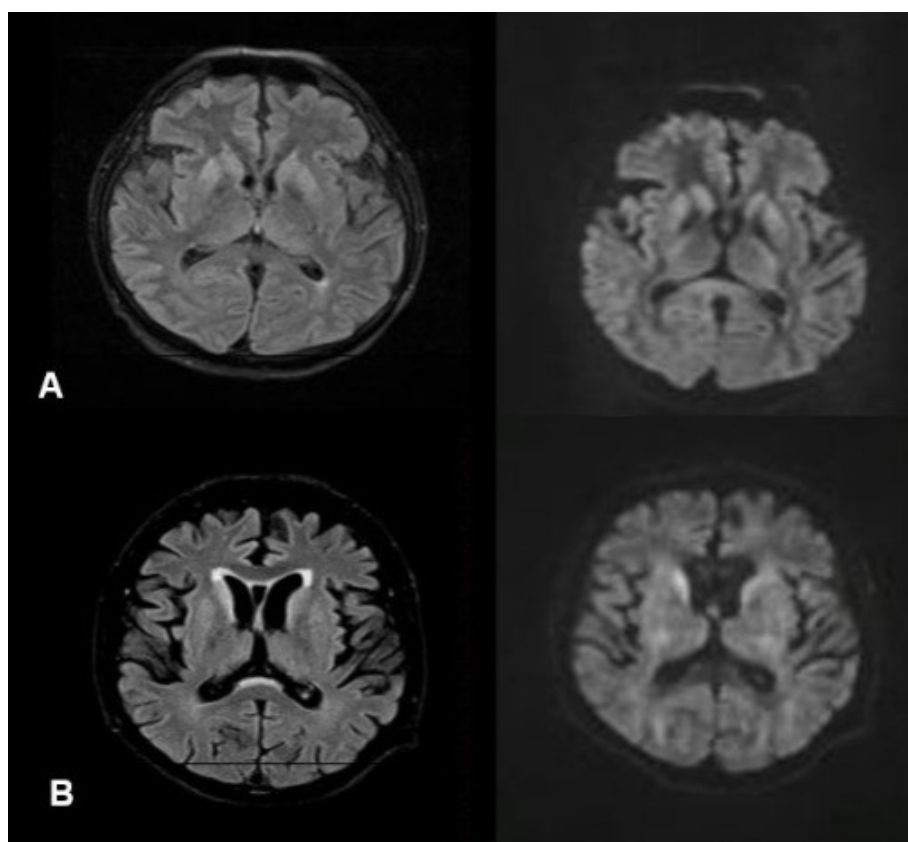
A) Brain MRI FLAIR and diffusion: Hypersignal and restriction, respectively, in caudate and putamen (Case 1). B) Brain MRI: Slight increase of intensity in FLAIR at the level of bilateral caudate nuclei, showing diffusion restriction. Moderate cerebral atrophy (Case 4).
